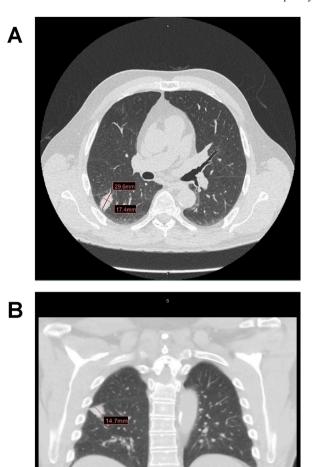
CT Chest at nine-month interval depicting a 3.0 by 1.7 cm right lower lobe mass in axial (panel A) and coronal views (panel B).
